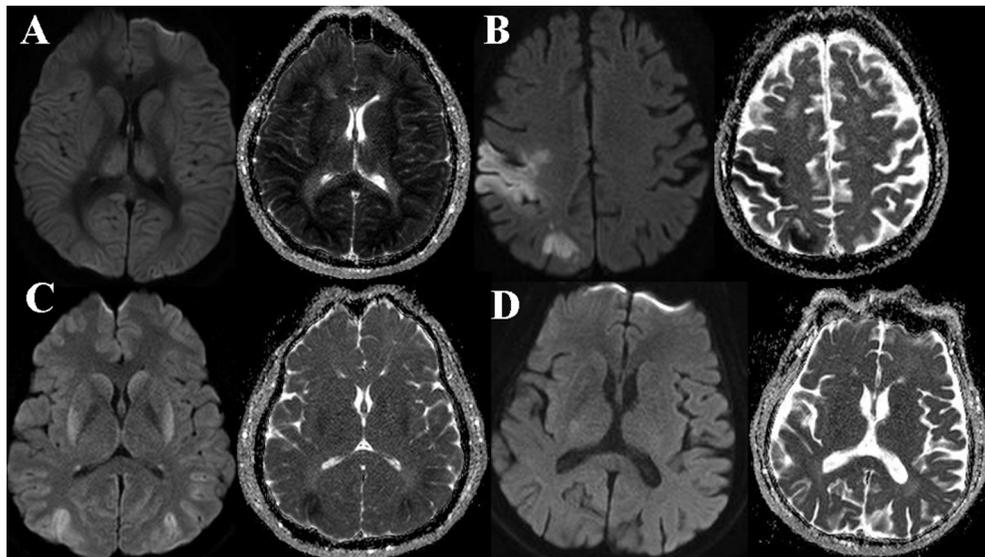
Representative brain DWI and corresponding ADC map within 3 h after hanging. (A) DWI of Case 1 (CA patient) in Table 2 showing diffuse high signal in the cortex and low signal in the corresponding ADC map. (B) DWI of non-CA patient showing the acute infarctions on left middle cerebral artery territory with low signal in ADC maps at the same levels. (C) DWI of case 12 (non-CA patient) in Table 2 showing the multifocal acute infarctions with low signal in ADC maps at the same levels. (D) DWI of case 14 (non-CA patient) in Table 2 showing normal findings.
